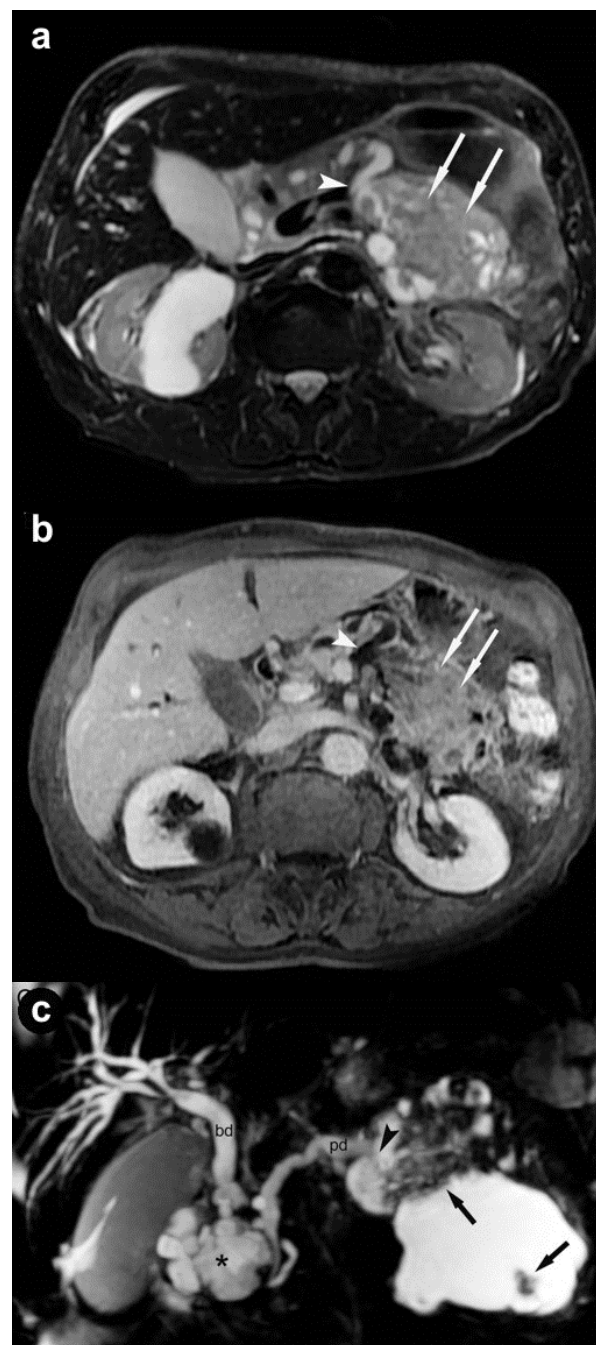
a. Axial T2-weighted image at the level of the pancreas shows the manifestation of the intraductal oncocyctic papillary neoplasm in the pancreatic tail. Communication to the pancreatic duct can be identified (arrowhead) as well as the hypointense solid tumor parts (arrows). b. Axial T1-weighted image after contrast enhancement with gadolinium at the same level also shows communication to the pancreatic duct and strong enhancement of the solid tumor parts (arrows). c. MRCP clearly depicts communication of the dilated pancreatic duct (pd) with the intraductal oncocyctic papillary neoplasm in the pancreatic head (asterisk) and tail (arrowhead); the solid tumor components are observable. (bd: dilated common bile duct).
